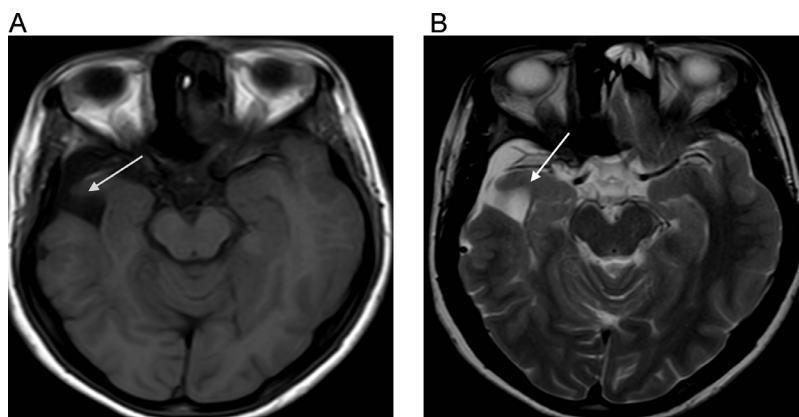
Axial MRI image at the level of midbrain showing cerebrospinal fluid signal intensity area in right anterior temporal pole communicating to the temporal horn of right lateral ventricle lined by grey matter (white arrow), as shown in T1 weighted (A) and T2 weighted (B) images.
